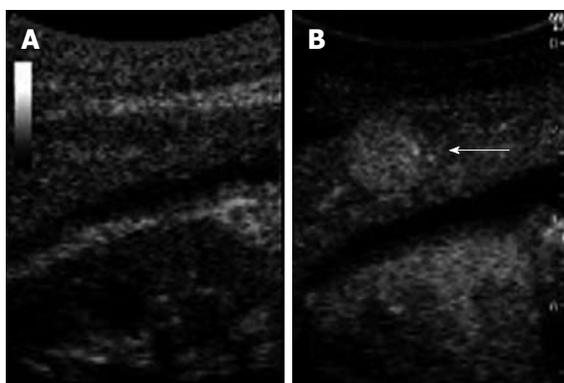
A 67-year-old man with a 1.5-cm hepatocellular carcinoma nodule located in segment 3 of the liver. A: B-mode ultrasound (US) cannot clearly depict the hepatocellular carcinoma (HCC) nodule; B: Contrast-enhanced US shows enhancement of HCC focus (arrow) in early vascular phase after administration of sonazoid.
